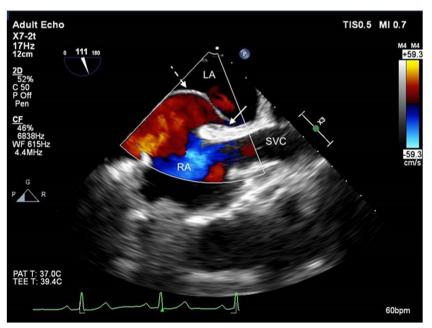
Transesophageal echocardiogram bicaval view showing a patent foramen ovale (solid arrow) with left to right shunt demonstrated by color Doppler, and an atrial septal aneurysm (dashed arrow). LA = left atrium, RA = right atrium, SVC = superior vena cava.
